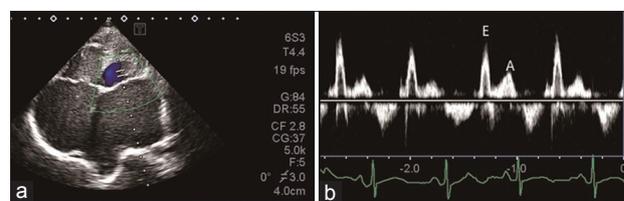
Echocardiography of restrictive cardiomyopathy. (a) Batrial enlargement, with normal ventricular chamber size; (b) peak E wave velocity, peak A wave velocity decreased significantly, and $E/A > 2$. E: Velocity of early filling mitral flow; A: Velocity of late filling mitral flow.
